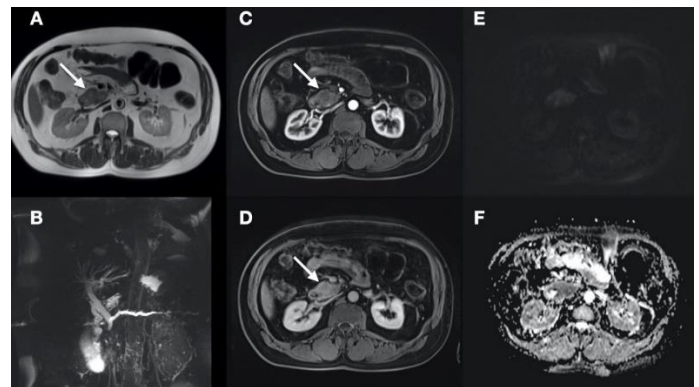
A 54-year-old male patient with poorly differentiated IPAC. The lesion displayed hyperintensity (white arrows) on the T2-weighted images (a-b) and continuous enhancement (white arrows) in the contrast-enhanced MRI sequences (c-d). Diffusion restriction was observed on the DWIs (e,f).
